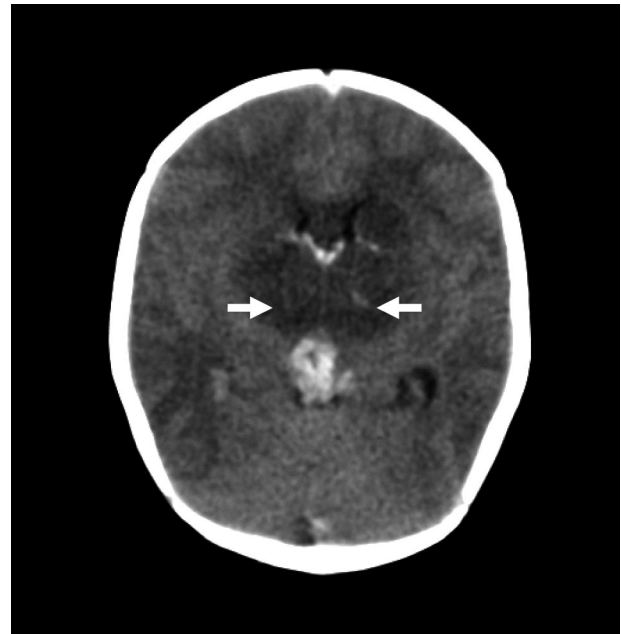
Noncontrast computed tomographic scan in a newborn with deep cerebral venous thrombosis and bilateral thalamic (white arrows) infarcts.
